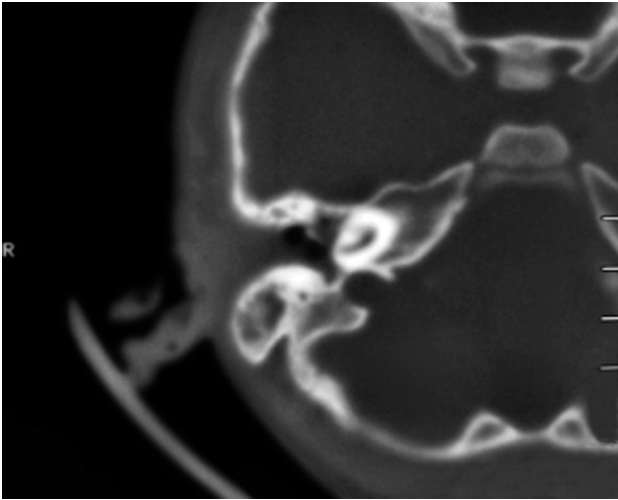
High resolution computed tomography of the temporal bone showing the cochlea and vestibule replaced by a cystic cavity.
